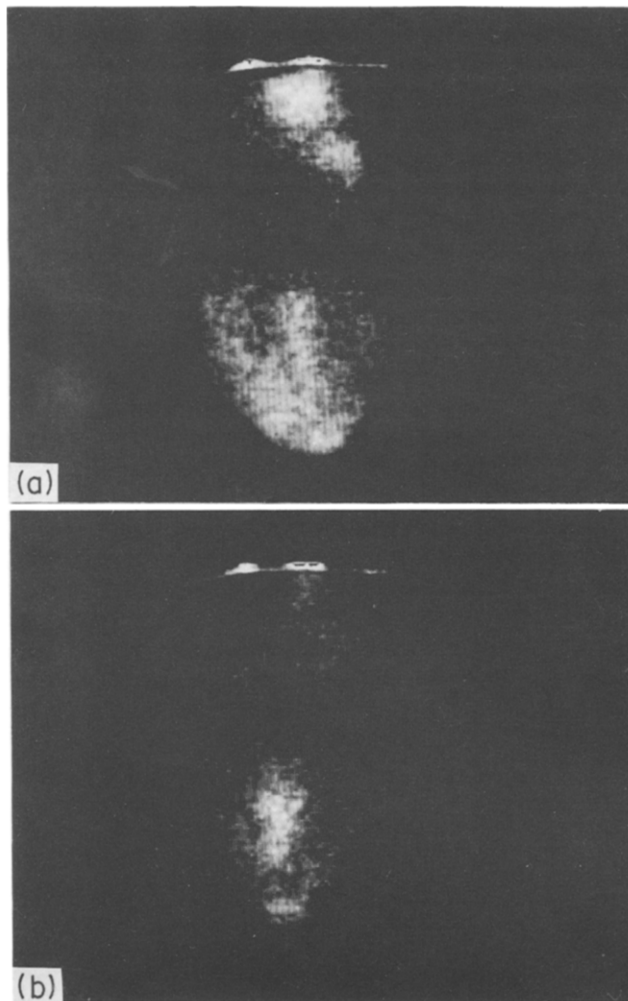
Pelvic immunoscintigraphic maps (anterior view) obtained 72 h after intraperitoneal administration of ^{131}I -MOv18 in patient no. 27. The tumour lesion infiltrating the bowel, barely visible (a) due to a persistent non-specific accumulation of radiotracer in the pelvis, became evident (b) after peritoneal washing.
